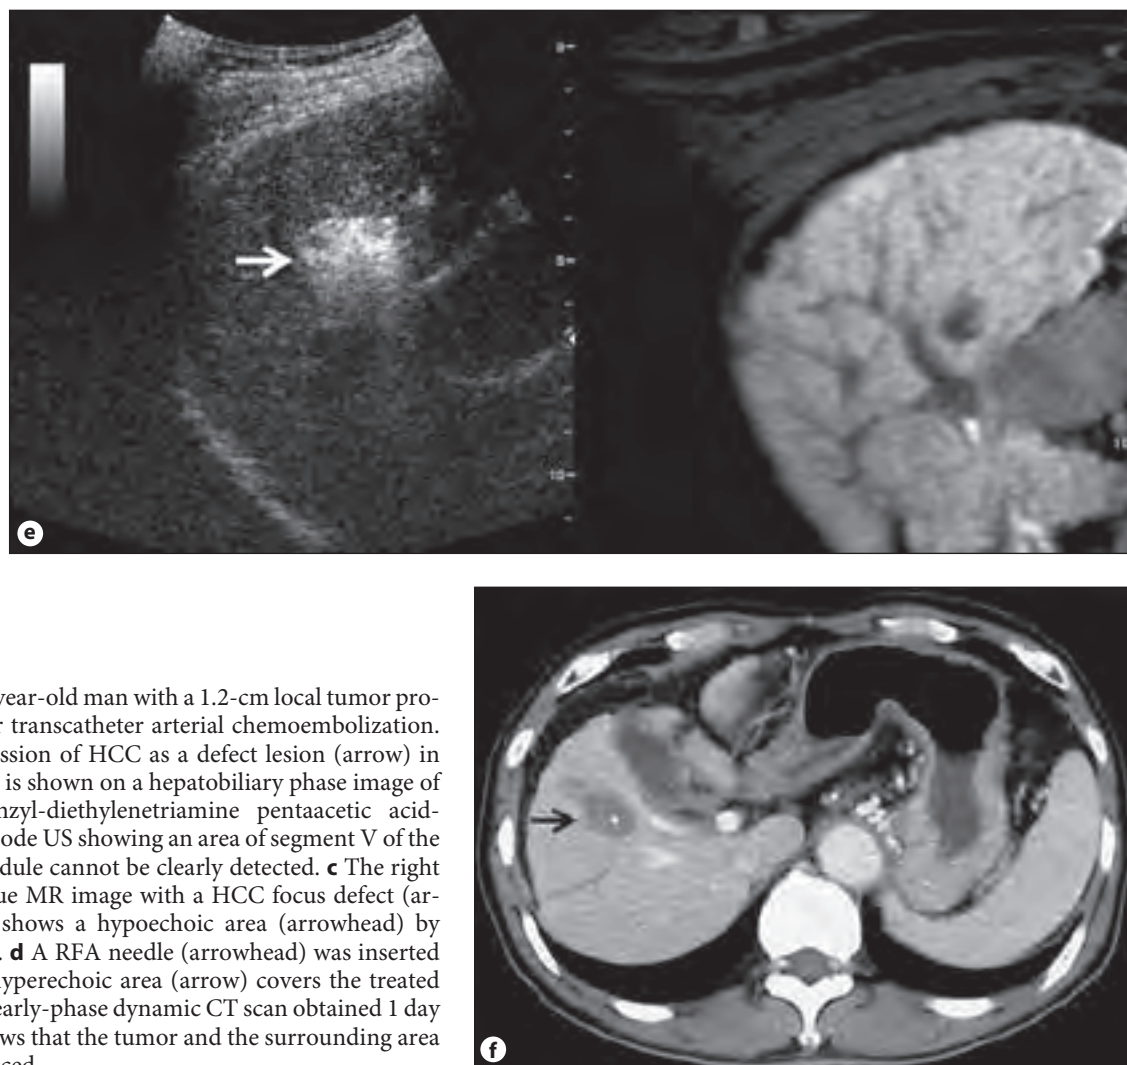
Images of a 61-year-old man with a 1.2-cm local tumor progression of HCC after transcatheter arterial chemoembolization. a Local tumor progression of HCC as a defect lesion (arrow) in segment V of the liver is shown on a hepatobiliary phase image of gadolinium-ethoxybenzyl-diethylenetriamine pentaacetic acid-enhanced MRI. b B-mode US showing an area of segment V of the liver, but the HCC nodule cannot be clearly detected. c The right panel shows an oblique MR image with a HCC focus defect (arrow). The left panel shows a hypoechoic area (arrowhead) by CEUS using sonazoid. d A RFA needle (arrowhead) was inserted in the defect. e The hyperechoic area (arrow) covers the treated HCC after RFA. f An early-phase dynamic CT scan obtained 1 day after RFA therapy shows that the tumor and the surrounding area (arrow) are not enhanced.
